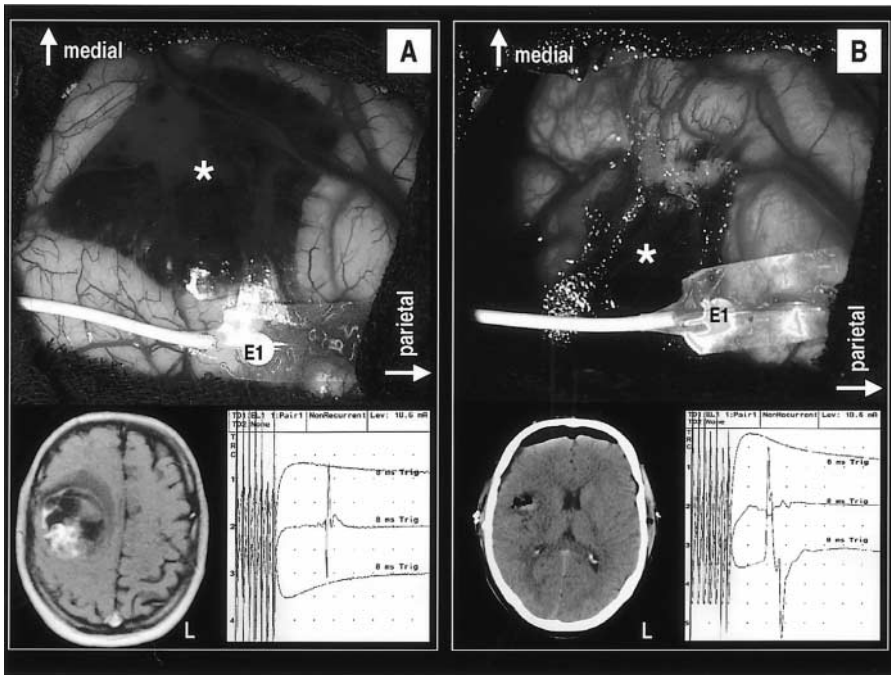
Case 1 – 32-year-old male with right frontal tumor (*PNET*). Intraoperative photography showing the strip electrode placed parietal to the tumor, partly located under the dorsal craniotomy borders and overlying the precentral gyrus. (A) before and (B) after tumor removal. Corresponding preoperative MR image and postoperative CT scan are shown below. The CMAPs elicited demonstrate lateral movement of the cortex underneath the unchanged electrode strip. *L* Left; *pr. g.* precentral gyrus; \* tumor; *E1* electrode No. 1
